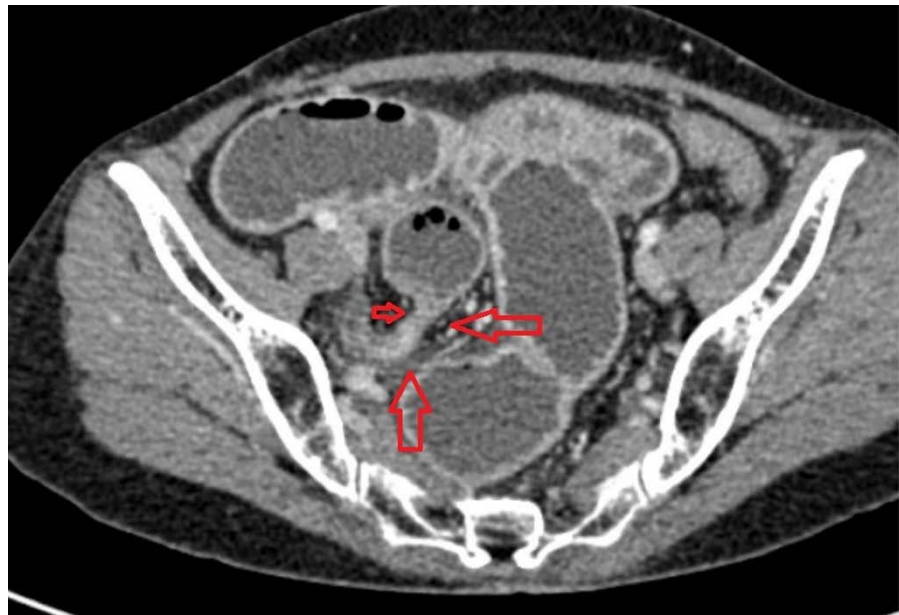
Axial abdominal CT showing the transition point between dilated bowel loop and collapsed loop (red arrows) [61]
